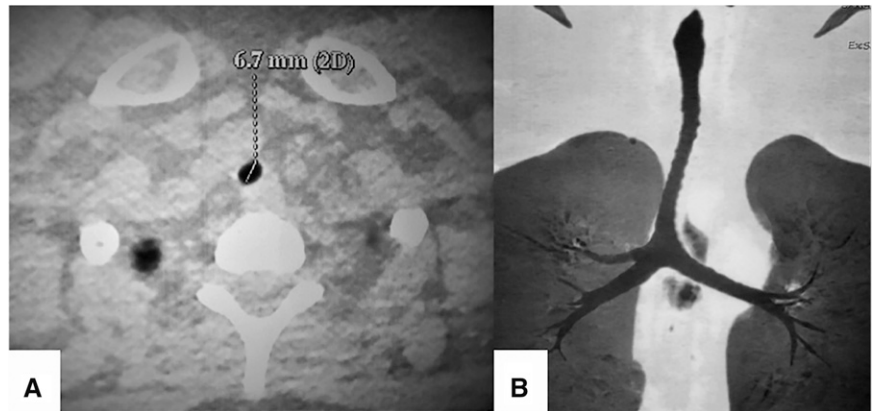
The computed tomography scan shows a tracheal constriction along the full tracheal length and a trifurcated main carina. (A) Transverse view of upper airway and trachea diameter. (B) Sagittal reconstruction of central airway and lungs.
